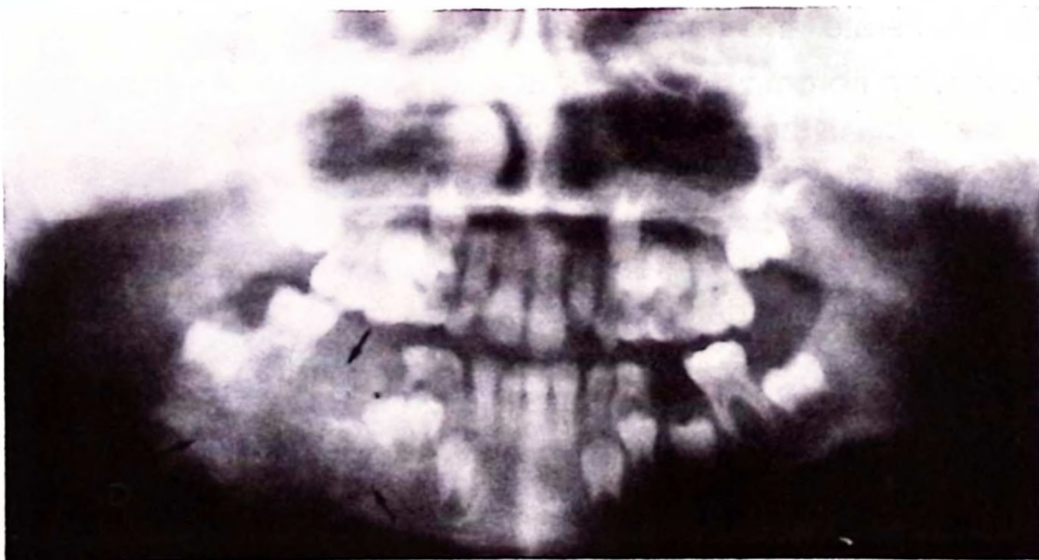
Panoramic radiographic view of the lesion in the right mandibular corpus (arrows).
